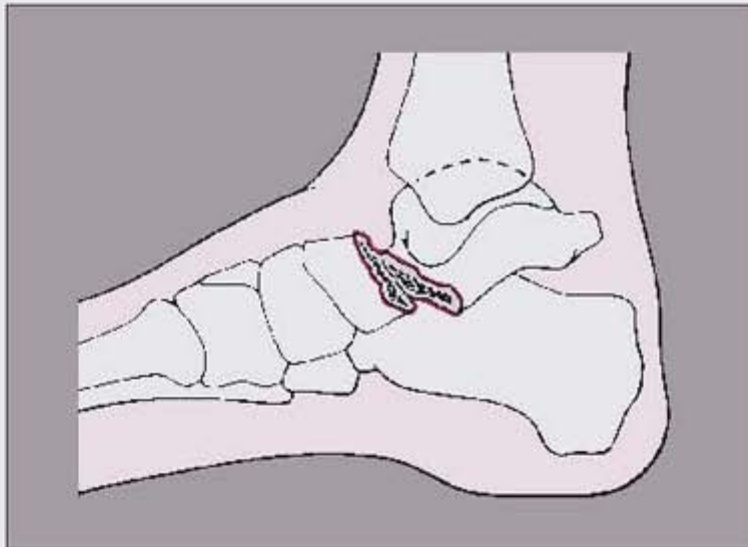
Stress fracture of the calcaneus. A 75-year-old woman reported pain in the left heel; she had no history of trauma. She walked about a mile to the supermarket every day. Lateral radiograph of the right foot shows a typical stress fracture of the os calcis.
